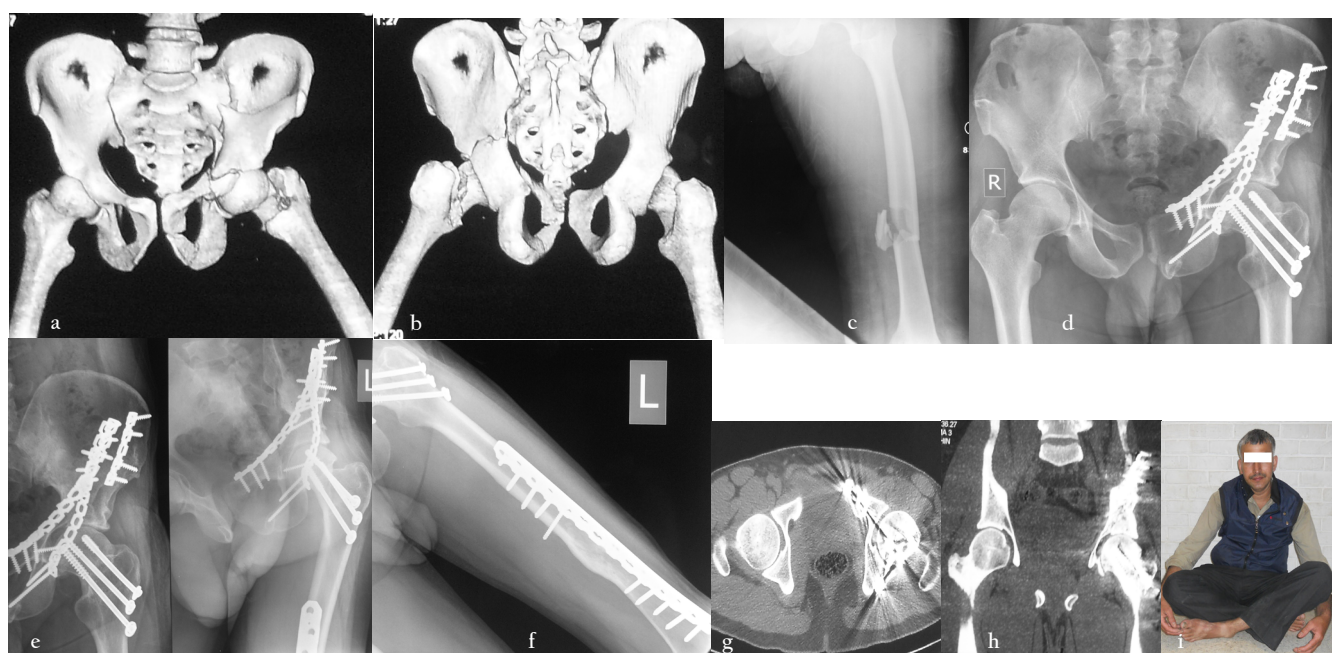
Transverse fracture with ipsilateral neck and shaft femur fracture. a to c: Pre operative X-rays and CT Scan, d to i: Follow up X-rays and CT scan and clinical picture at 26 months
